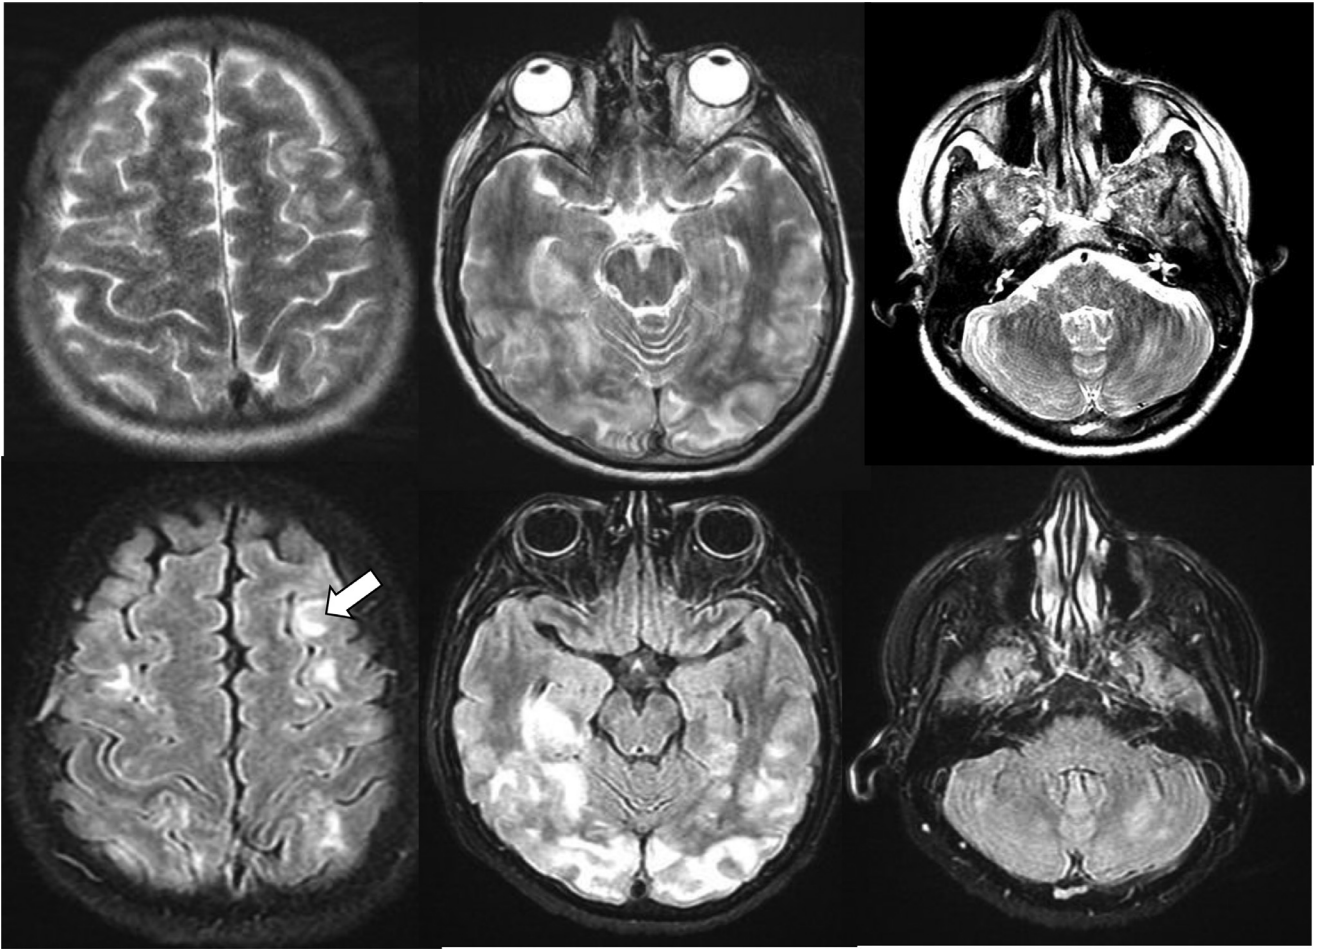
Axial magnetic resonance image T2 (first row) and FLAIR (second row) demonstrating supra and infratentorial white matter high T2/FLAIR signal abnormalities with involvement of juxta cortical and U fibers (White arrow). NB: motion artefact is noted.
